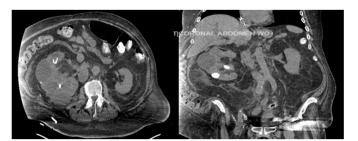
Computed Tomography of the abdomen and pelvis with oral contrast.
